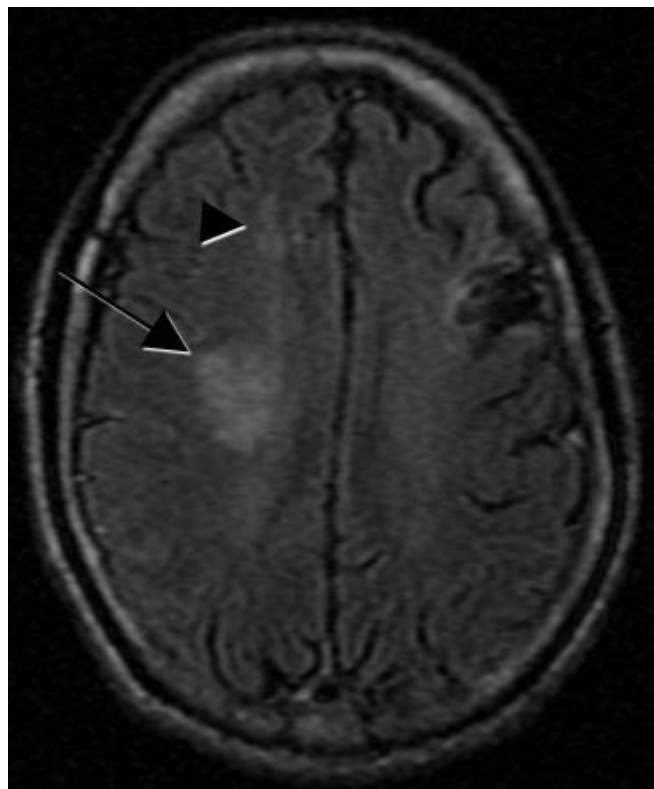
Brain MRI without contrast (axial Flair sequence): Acute or subacute right centrum semiovale infarct (arrow) with a small focal area of probable lacunar infarct in the right frontal lobe (arrowhead).
